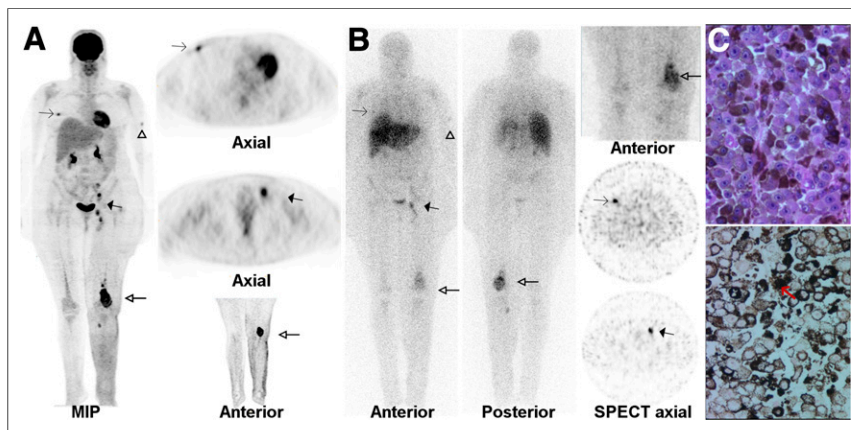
A 53-y-old woman with past history of pigmented melanoma of left leg. (A) At inclusion, ^{18}F -FDG PET revealed high-intensity ^{18}F -FDG uptake in right intramammary mass (thin arrows), subcutaneous nodule of left arm (arrowhead), left iliac/femoral lymph node (thick solid arrows), and large left popliteal/femoral/tibial mass (thick open arrows). (B) All lesions were also visualized on ^{123}I -BZA2 planar/whole-body scans and SPECT slices. (C) Standard coloration of popliteal mass biopsy showed melanoma metastases with epithelioid appearance (top). Fontana-Masson coloration (bottom) confirmed high cytoplasmic melanin content (red arrow). MIP = maximum-intensity projection.
